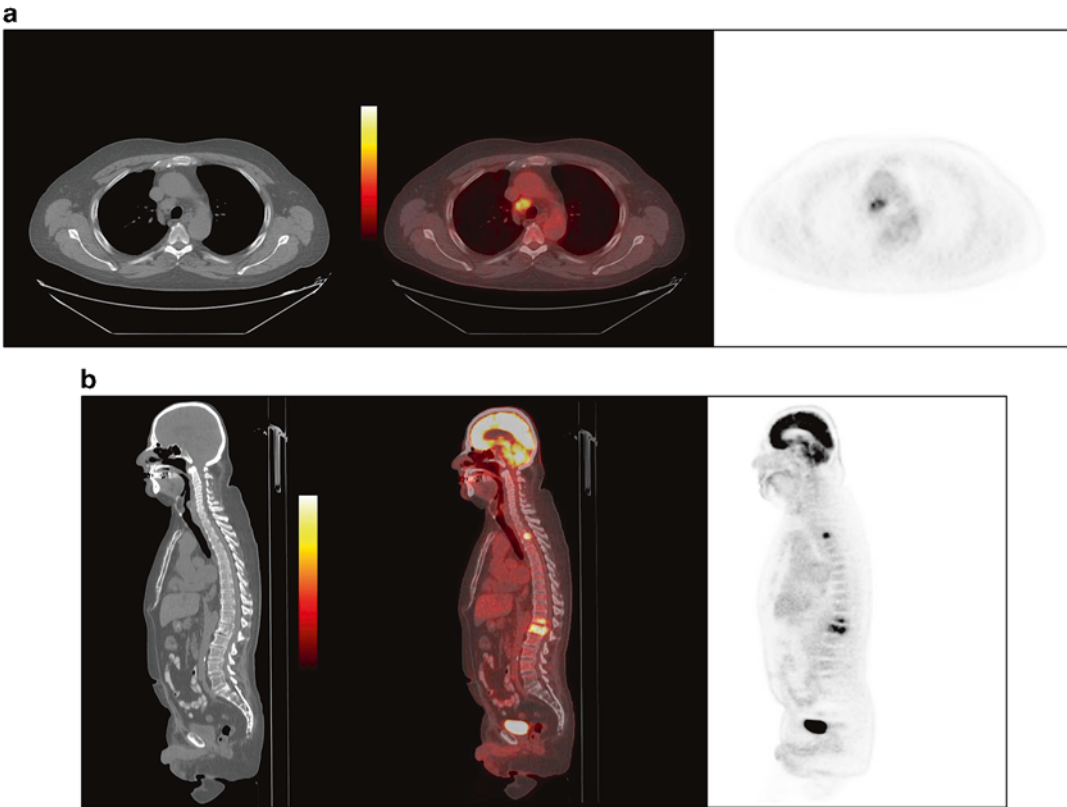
A 66-year-old male with advanced metastatic CRPC on FDG PET/CT demonstrates an FDG-avid (a) right paratracheal metastatic lymph node and (b) vertebral body bone metastases (T3, T12, L1)
